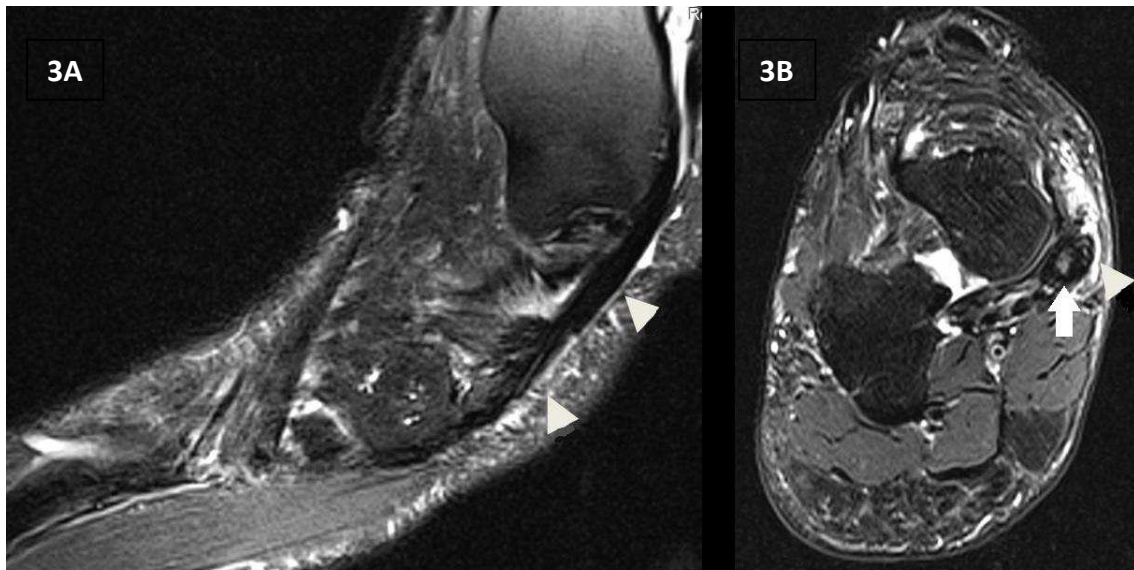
A and B show fat saturated T2w images in the sagittal and axial plane respectively. Tenosynovitis of tibialis posterior defined high signal on T2-weighted in a region of the tendon (white arrow) and the enclosing tendon sheath (white arrow head) in two planes was shown. This was scored as grade 2 (>2 and <5 mm peritendinous effusion and/or thickening and high intra-tendinous signal intensity).
